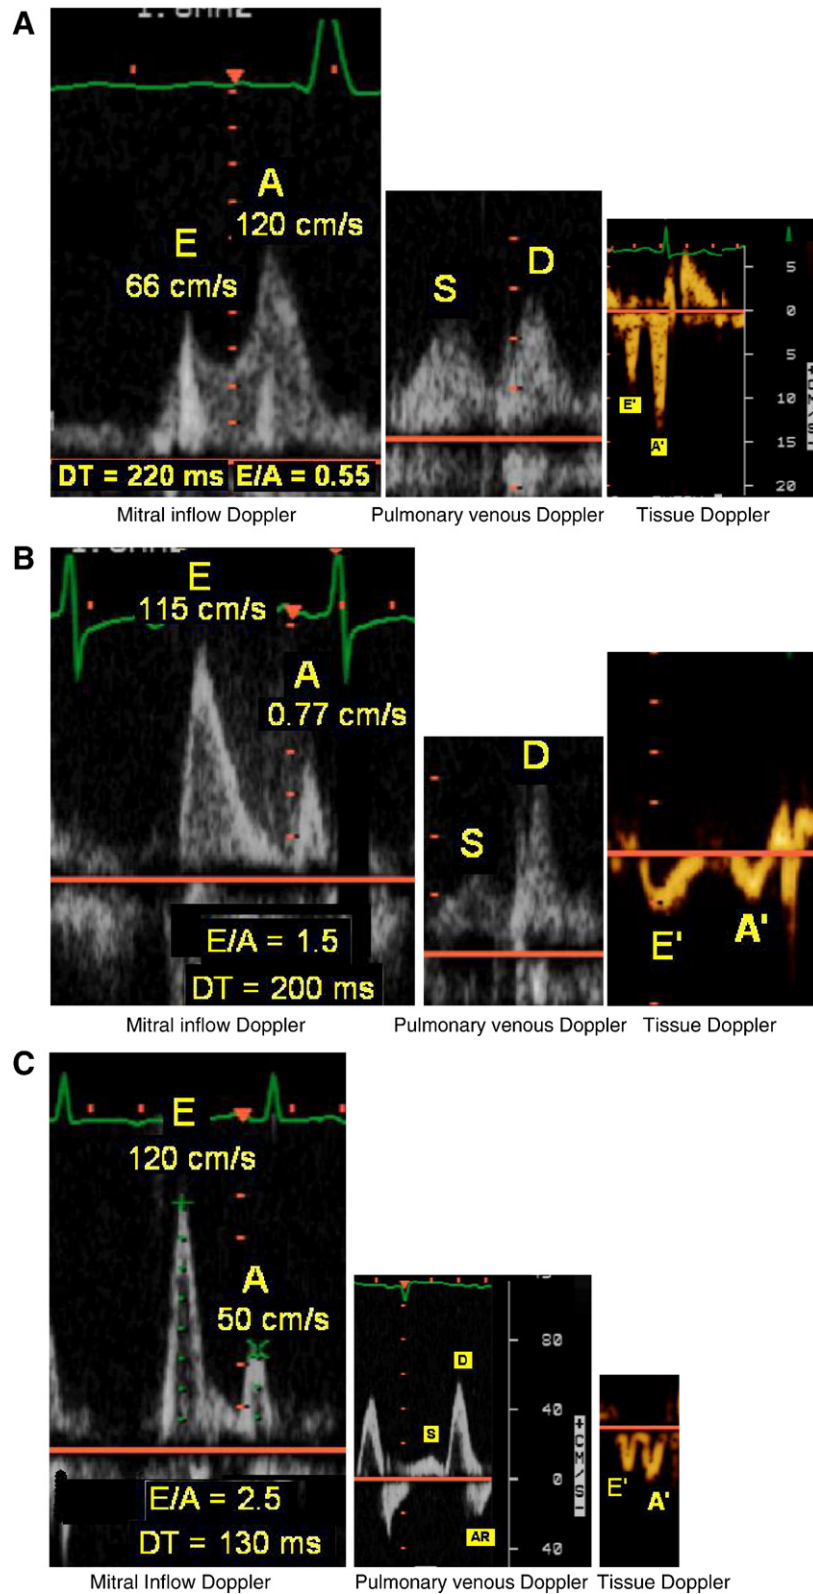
(A) Grade 1 diastolic dysfunction. The mitral inflow Doppler reveals reversal of the E/A ratio. The pulmonary venous Doppler shows slight predominance of the diastolic flow component. The tissue Doppler demonstrates  $E' < A'$ . (B) Grade 2 diastolic dysfunction. Mitral inflow Doppler shows a “pseudo-normal” pattern. The pulmonary vein Doppler shows dominance of the diastolic component and the tissue Doppler velocities are low. The abnormal tissue and pulmonary vein Doppler distinguish this pseudo-normal mitral inflow pattern from a truly normal pattern. (C) Grade 3 diastolic dysfunction. The mitral Doppler shows a tall E wave with increased E/A ratio of 2.5. In addition the deceleration time (DT) is shortened. The pulmonary vein Doppler imaging shows marked predominance of the diastolic component and increase in the duration of pulmonary vein atrial flow reversal wave (AR). The corresponding tissue Doppler shows very low velocities.
